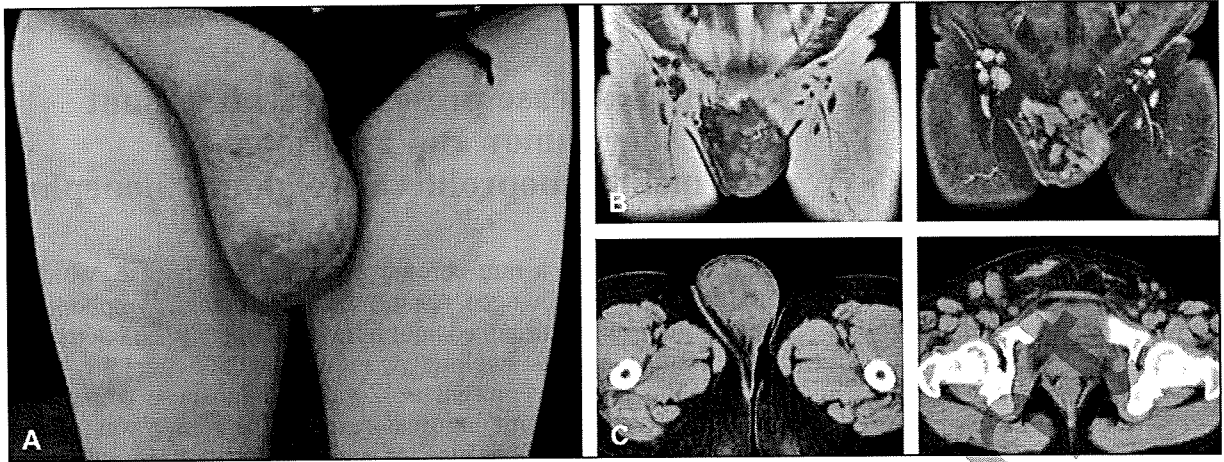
Clinical appearance, magnetic resonance image and computed tomography. A) A large suspensory tumor on the right inguinal region. B) There is an iso-high intensive mass on the groin region (left, T1 intensity), and some irregular nodules are seen in the mass (right, T2 intensity). C) There is an inarticulate tumor in the right groin to genitocrural region (left), and swollen lymph nodes are seen in the both groin areas (right).
